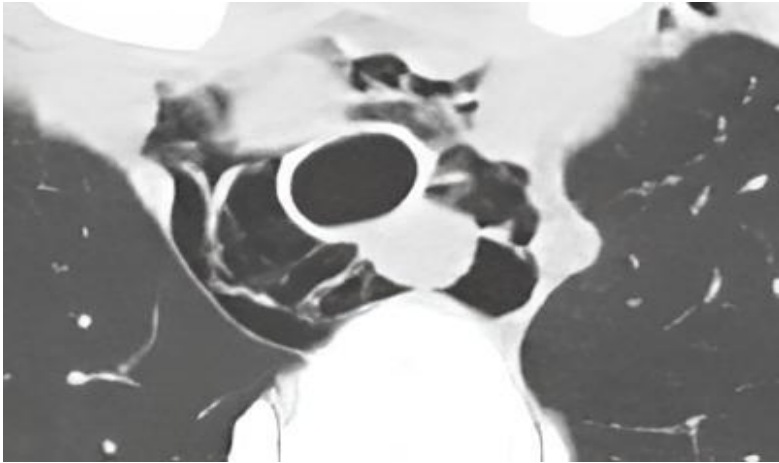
Grade 1 pneumomediastinum: Air localized in the superior paratracheal region on an axial CT image
